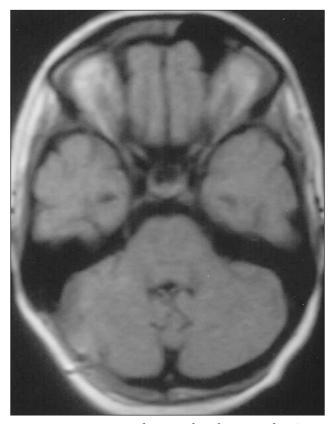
Postop. MRI showing that the tumor has been totally removed.
